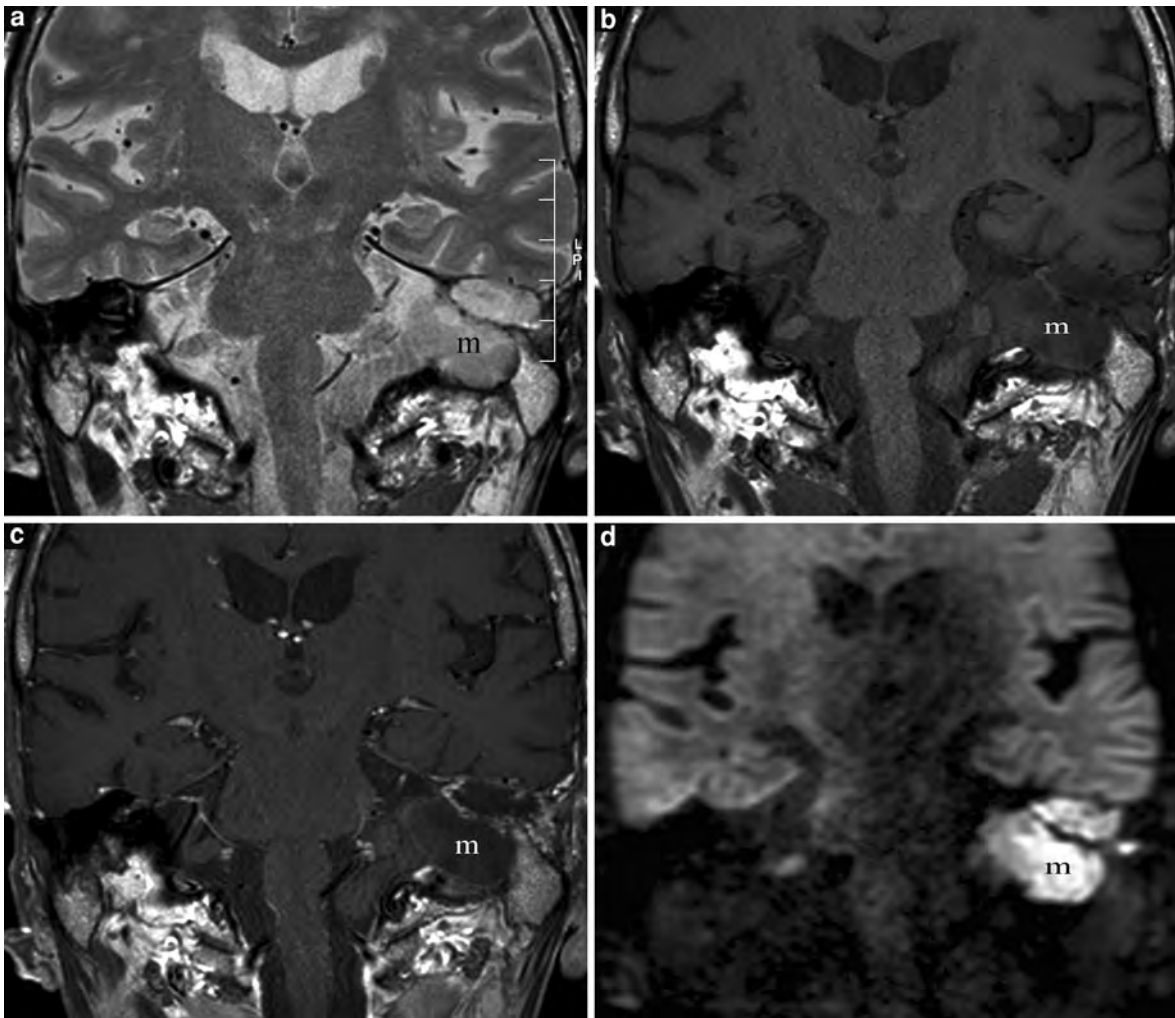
Coronal T2-weighted image (a) demonstrates a large, hyperintense mass (*m* in a) in the right petrous apex region on the left side that might be mistaken for a chondrosarcoma because of its location and T2 signal intensity. The T1-weighted images pre- (b) and post-contrast administration (c), however, show lack of enhancement within the mass
